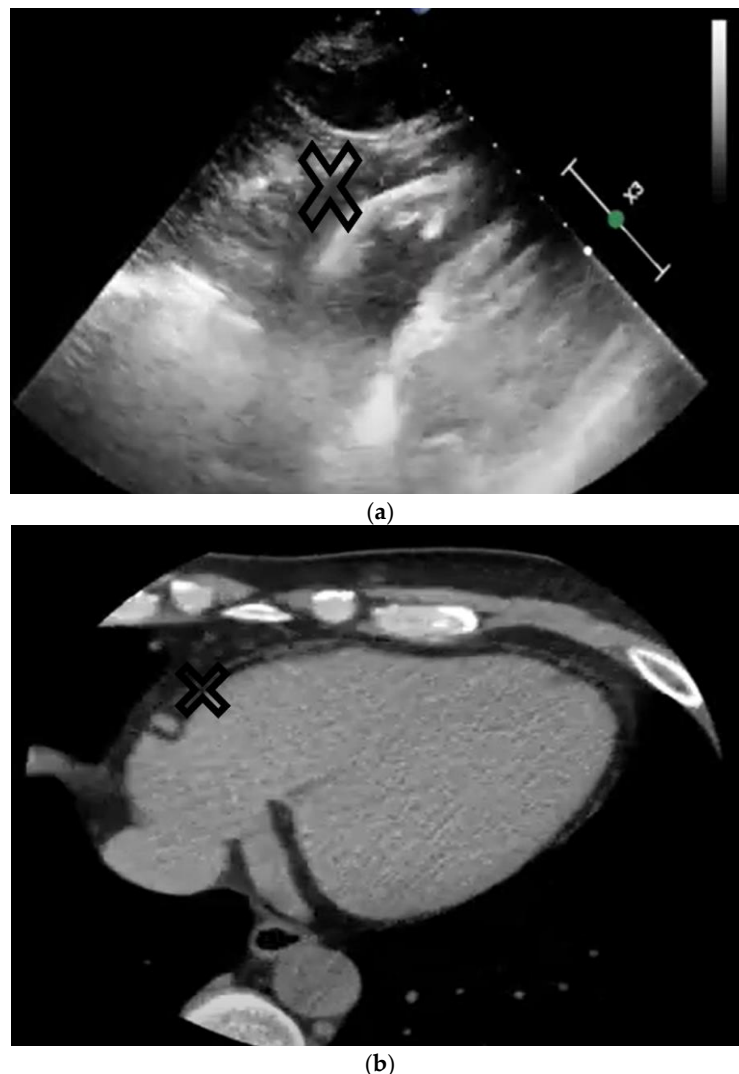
The upper image (a) represents a subxiphoid echo view of the heart, and the lower image (b) represents a CT view of the heart. The epicardial adipose tissue is marked on both images with X.
